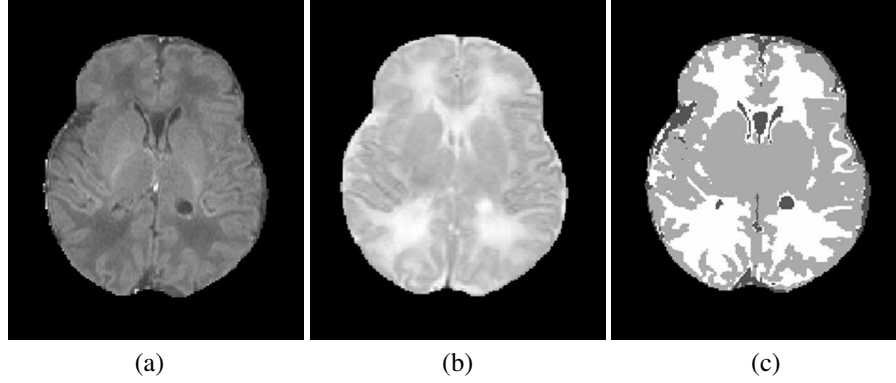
Real neonatal MR brain image: (a) and (b) original T_1 -W and T_2 -W MR images respectively; (c) the multimodal SCFCM segmentation of the neonatal brain in three tissues: WM (white segment), GM (light gray segment) and CSF (dark gray segment).
